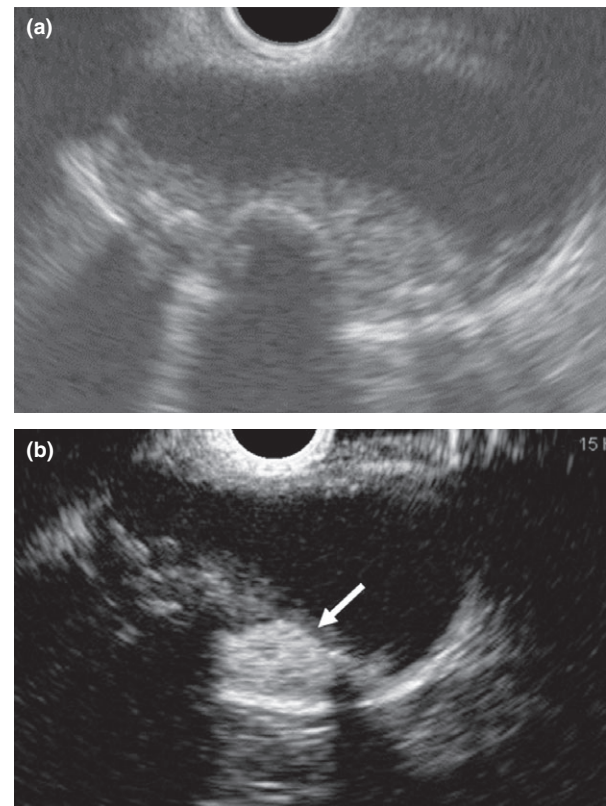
Case with a cholesterol polyp hidden by biliary sludge. (a) Fundamental B-mode endoscopic ultrasonography (monitor mode). A high echoic structure with acoustic shadow can be seen in the gallbladder. (b) Contrast-enhanced harmonic endoscopic ultrasonography (CH-EUS). The majority of the lesion is not enhanced by CH-EUS, but the polypoid lesion is incidentally detected in the center of the lesion as a homogeneous enhancement with spotty vessels (arrow).
